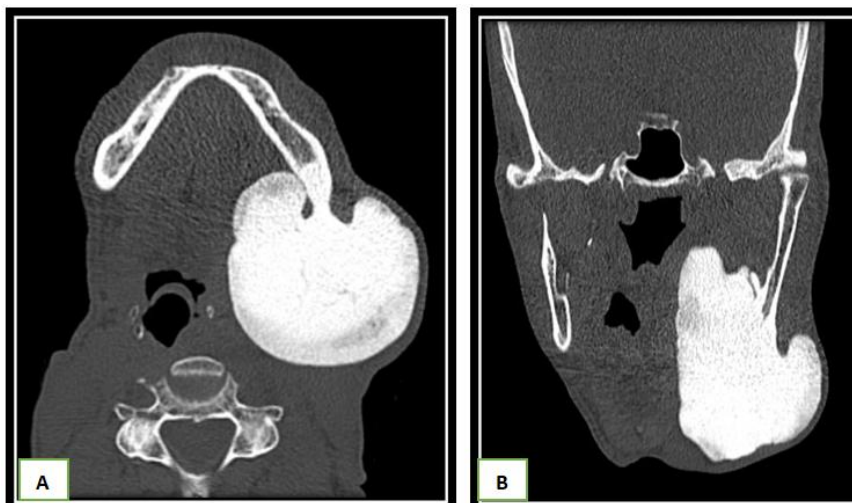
Axial (A) and coronal (B) sections of the bone window of a cervico-facial CT scan: lesion of the left mandibular angle, dense and homogeneous bone matrix, with clear contours and lobulated, appended to the lower mandibular cortical which is thickened with condensation of the bone marrow opposite
